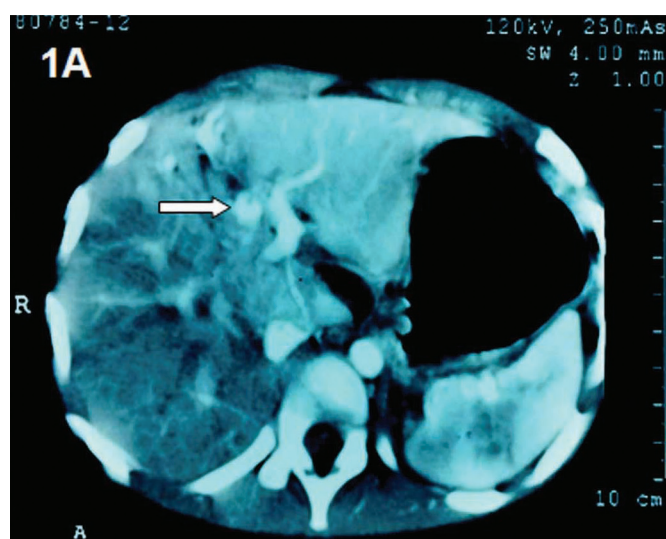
CT scan showing pseudoaneurysm (arrow) of the left hepatic artery in the lacerated area of segment IV.
